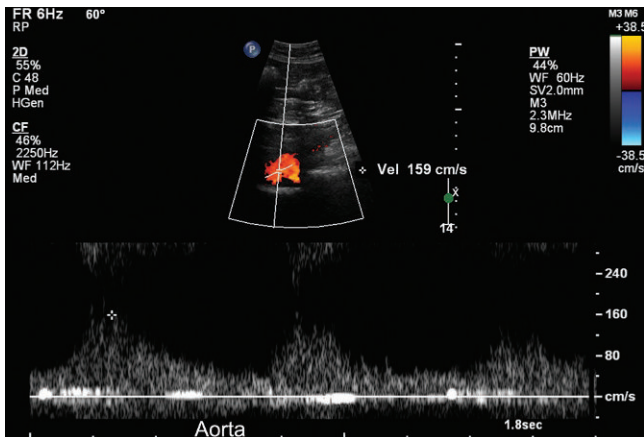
Spectral Doppler of the aorta above the renal artery shows a slow upstroke and gradual downslope. The finding indicates upstream obstruction. In this case the obstruction was in the thoracic aorta from aortic coarctation.
